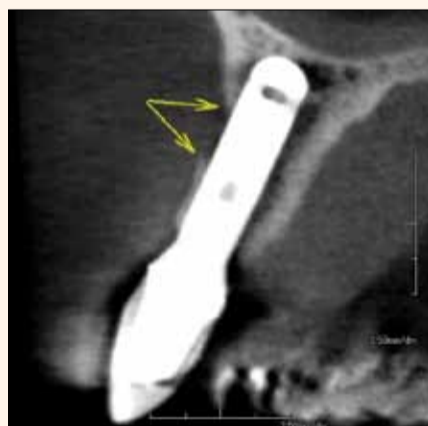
Sagittal CBCT MPR showing bone defect at point of dehiscence of the implant coating.
